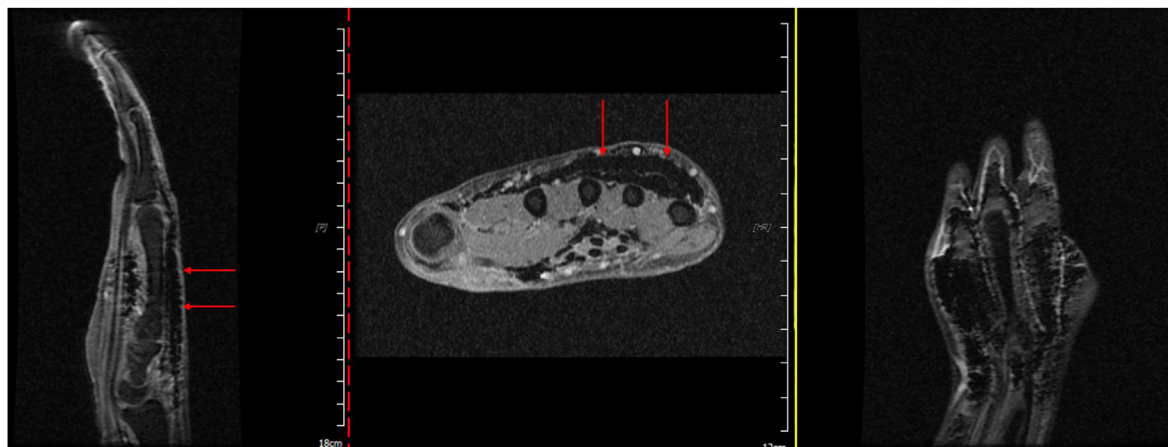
T₁-weighted fat saturated MRI sequences (sagittal, axial, and coronal views) demonstrating subcutaneous air along the dorsal surface of the hand superficial to the third through fifth digits without involvement of the flexor tendons.
